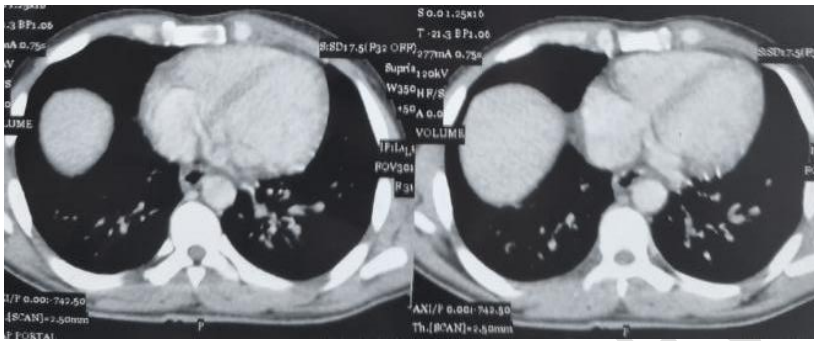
Chest computed tomography scan showed disseminated micronodular lesions, a thickened interlobular septa and mediastinal lymphadenopathies.
